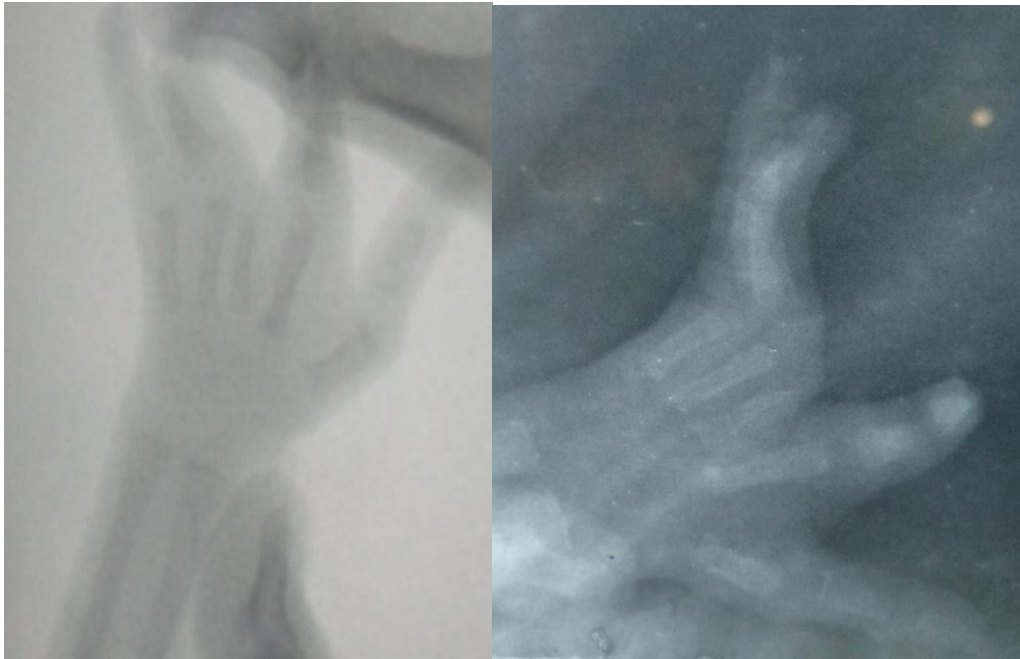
Fluoroscopic and plain radiographic images of the right-hand demonstrating partial fusion of the soft tissues of the 4th web space proximally with associated absence of the 3rd digit. The remaining demonstrated bones appear within normal limit. Note however the digits of the care-giver to stabilize the patient's hand for the imaging.
